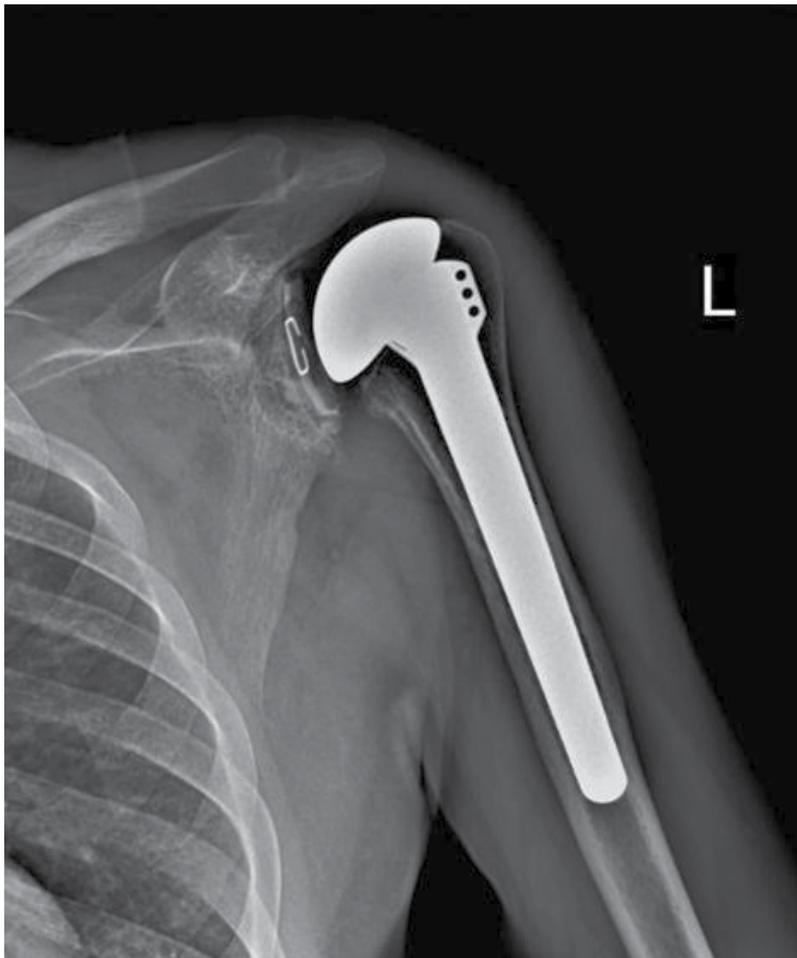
A shoulder radiograph (anterior-posterior view) of 60 years old male patient, three years after cemented TSA. Lucency is evident in the direct proximity to the glenoid component, but the patient is pain free and has good range of movements of the operated shoulder, without any laboratory evidence of infection and is satisfied from the function of the operated shoulder.
